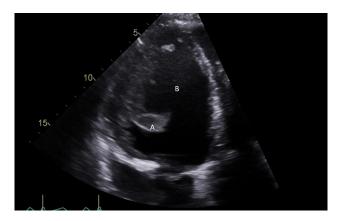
Apical 4-chamber TTE images demonstrated a large LV thrombus (A) attached to the lateral wall. (B) LV.
